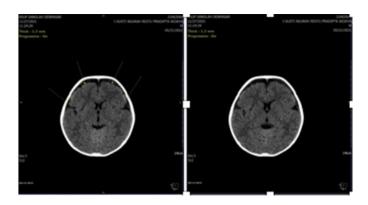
Head CT Scan without contrast
